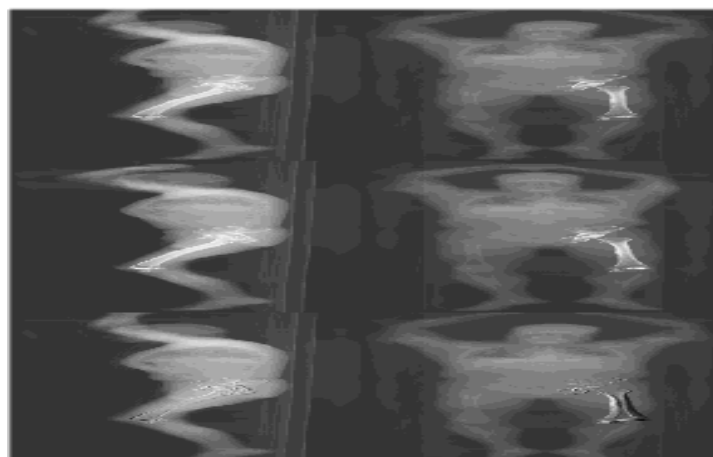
Correspondence of two regions of interest, from two different intra-subject CT volumes, derived from segmentation (right femur). Images are total projections in coronal (left) and sagittal (right) directions. Upper and middle images are from volume 1 and 2 respectively and bottom image is the difference between volumes.
